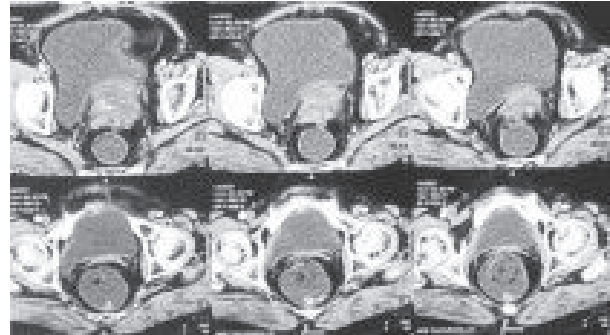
CT scan showing pelvic recurrence in transverse view of the pelvis
